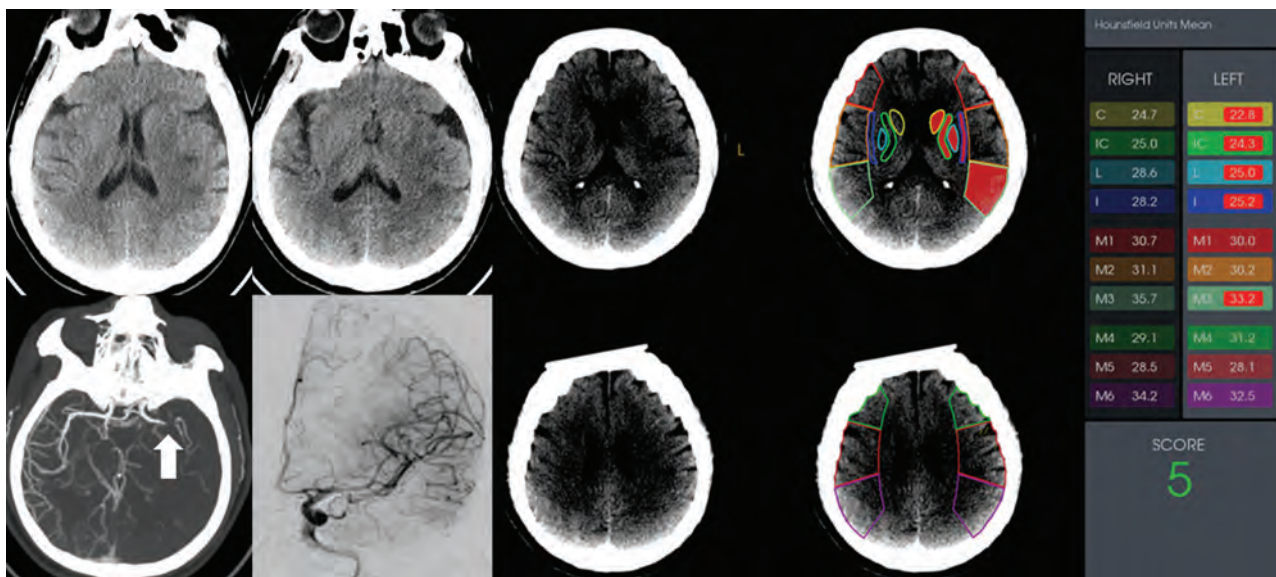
A patient with acute ischemic stroke due to occlusion of the M1 segment of the left MCA. This patient had an NIHSS score of 15 at admission and a low ASPECTS of 5. The mean value of ASPECTS-NWU at admission CT was 8.2%. Complete revascularization (mTICI grade 3) was achieved after mechanical thrombectomy. This patient had a favorable outcome, with an mRS score of 1 at 90 days. C indicates caudate nucleus; IC, internal capsule; L, lenticular nucleus; I, insula.
